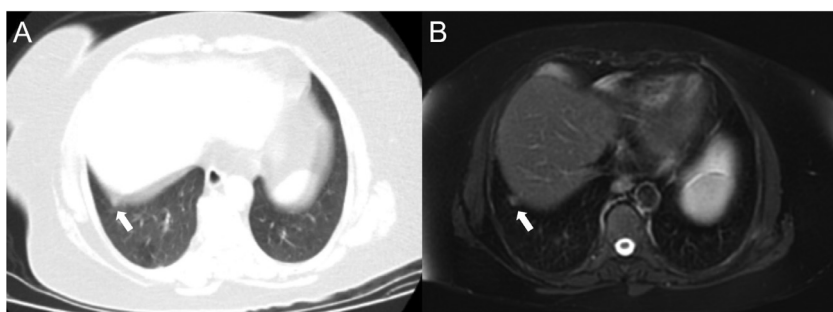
A 59-year-old female patient presenting with a nodule (arrow) that is considerably affected by a motion artifact due to its adjacency to the diaphragm in CT examination (a) but can be easily seen on the T2 FSE PROPELLER MRI image due to respiratory gating (b).
